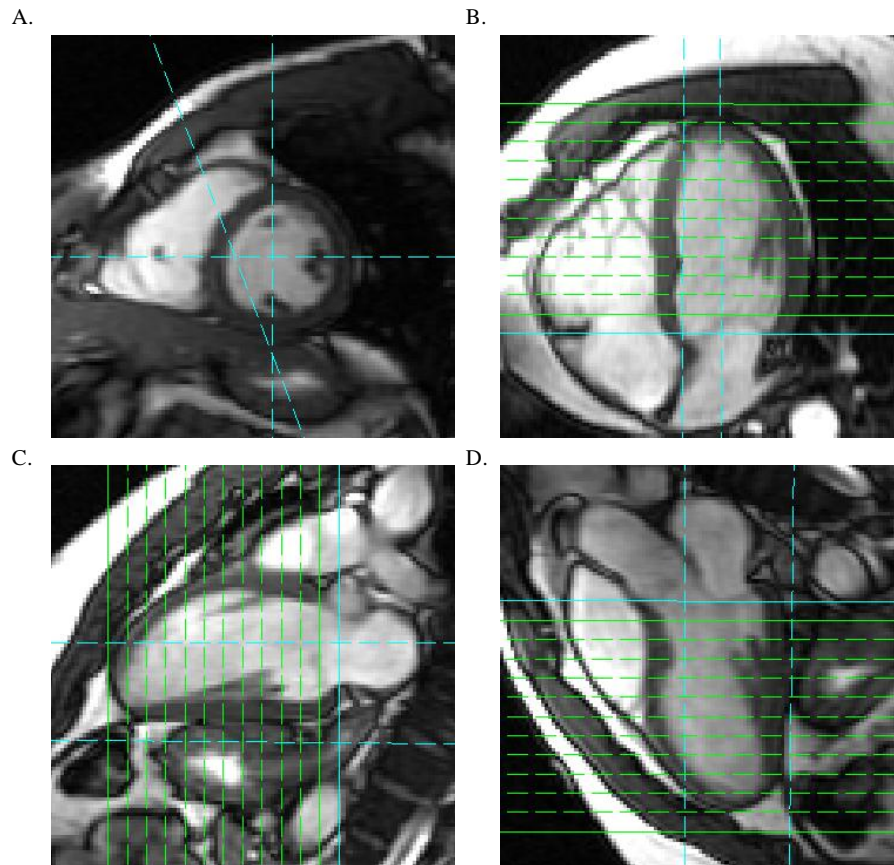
Cine MRI slice prescriptions
